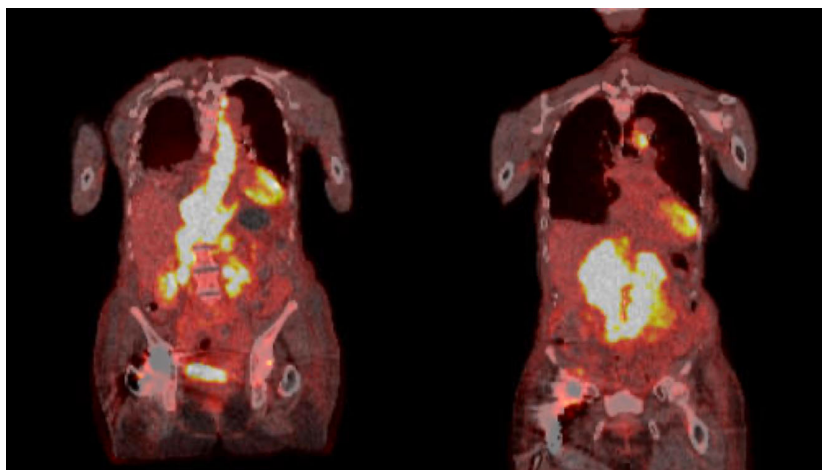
Selected PET/CT scan images at the time of plasmablastic lymphoma transformation. PET/CT, Positron emission tomography/computed tomography.
